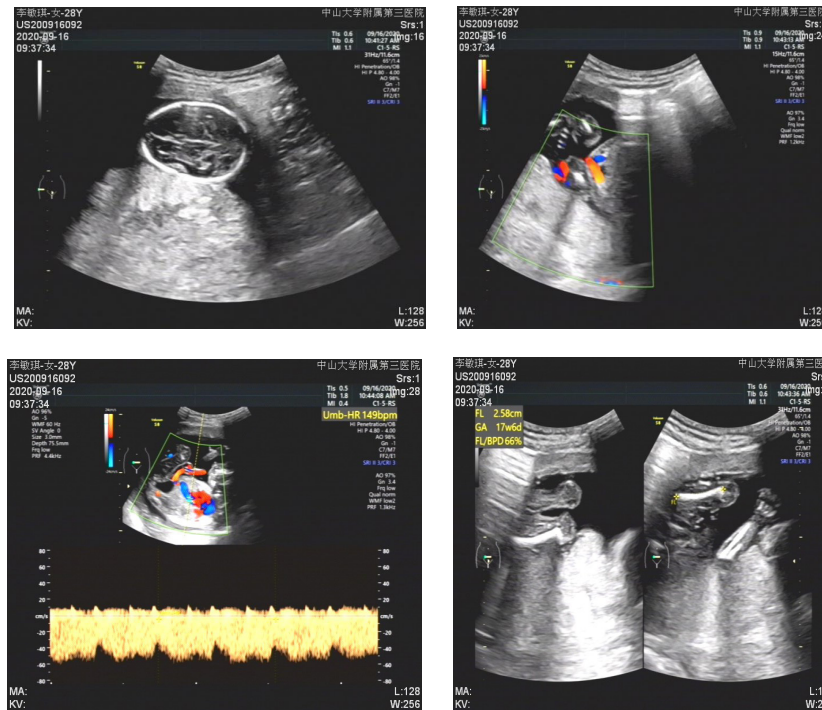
Obstetrical ultrasound showing: 1. Intrauterine gestation and singleton alive. On measurement, the fetus size is consistent with gestational age. 2. Placenta grade 0. Amniotic fluid amount is normal. 3. The posterior wall of the uterus is significantly thickened suggesting adenomyosis. 4. Endocervical canal is opened as U shape with length of 11 mm and width of 20 mm. Length of other part of cervix is 7 mm. 5. The intestines are dilated. Gas and liquid levels are found in the intestine with a small amount of peritoneal effusion indicating intestinal obstruction.
